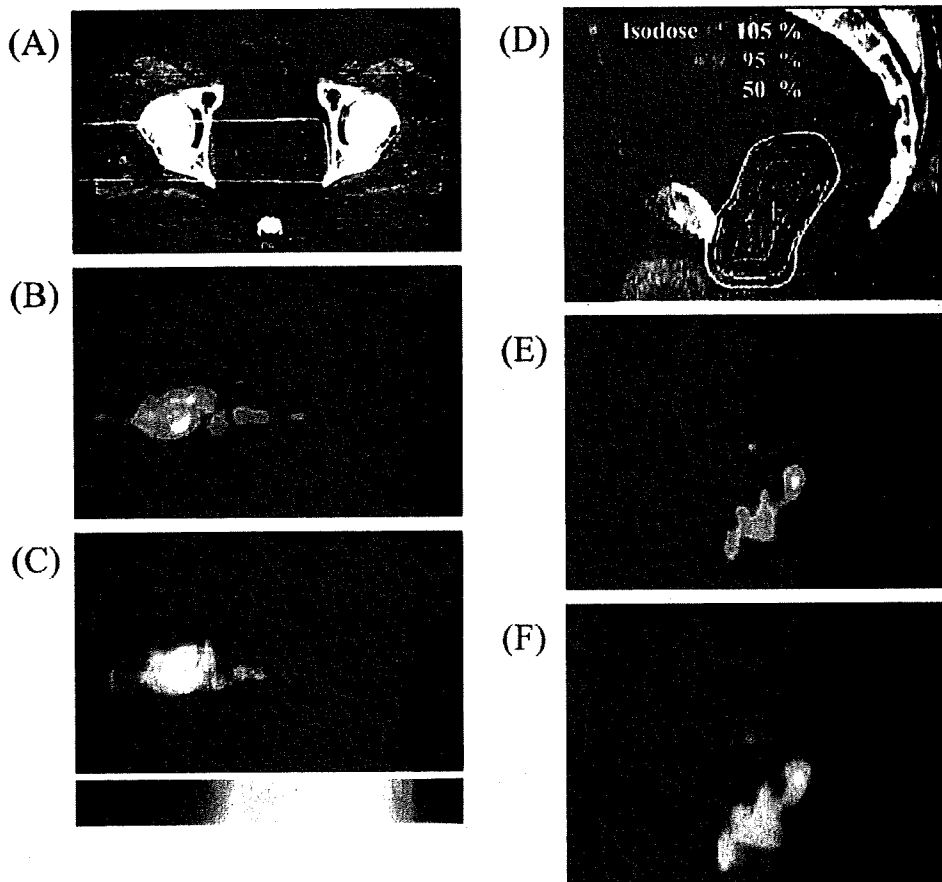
Comparison of isodose curves and distribution of autoactivation in patients with prostate cancer (A) Axial image of calculated dose distribution in upper planning target volume (PTV) level. (B) Axial image of distribution of autoactivation in same PTV level. (C) Axial positron emission tomography (PET)/computed tomography (CT) fusion image. (D) Sagittal image of dose distribution (E) Sagittal image of distribution of autoactivation (F) Sagittal PET/CT fusion image.
